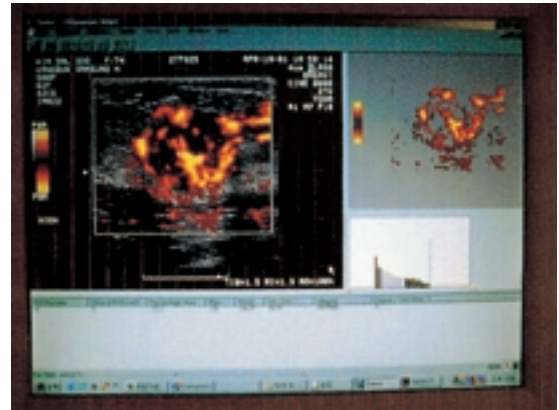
Calculation of the amount of Doppler signals on the personal computer by using computer-assisted program (sonic v10R).
